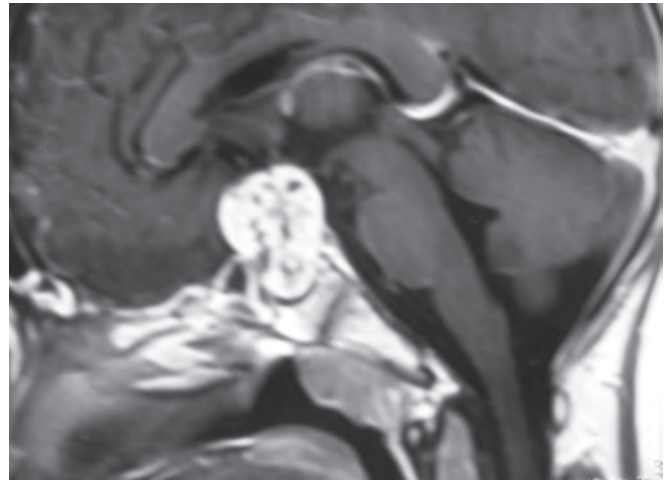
Magnetic resonance imaging showing suprasellar lesion going totally into the sella
